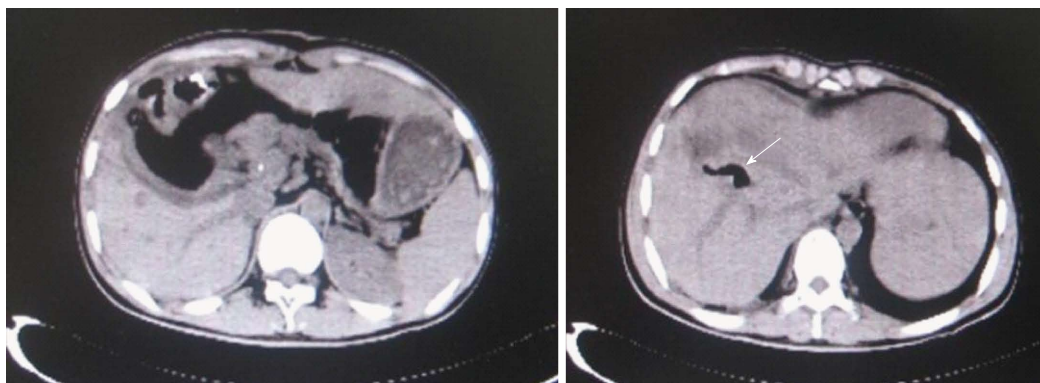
Abdominal computed tomography shows pneumatosis in the intrahepatic bile duct after cyst excision, cholecystectomy and Roux-en-Y hepaticojejunostomy reconstruction (white arrow). The intrahepatic dilatation tends to reduce in size following sufficient biliary drainage.
